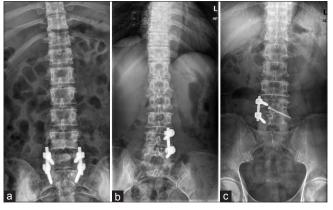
X-ray exams after the operations. (a) Transforaminal lumbar interbody fusion with bilateral pedicle screw fixation; (b) transforaminal lumbar interbody fusion with unilateral pedicle screw fixation; (c) transforaminal lumbar interbody fusion with UPSFS fixation
